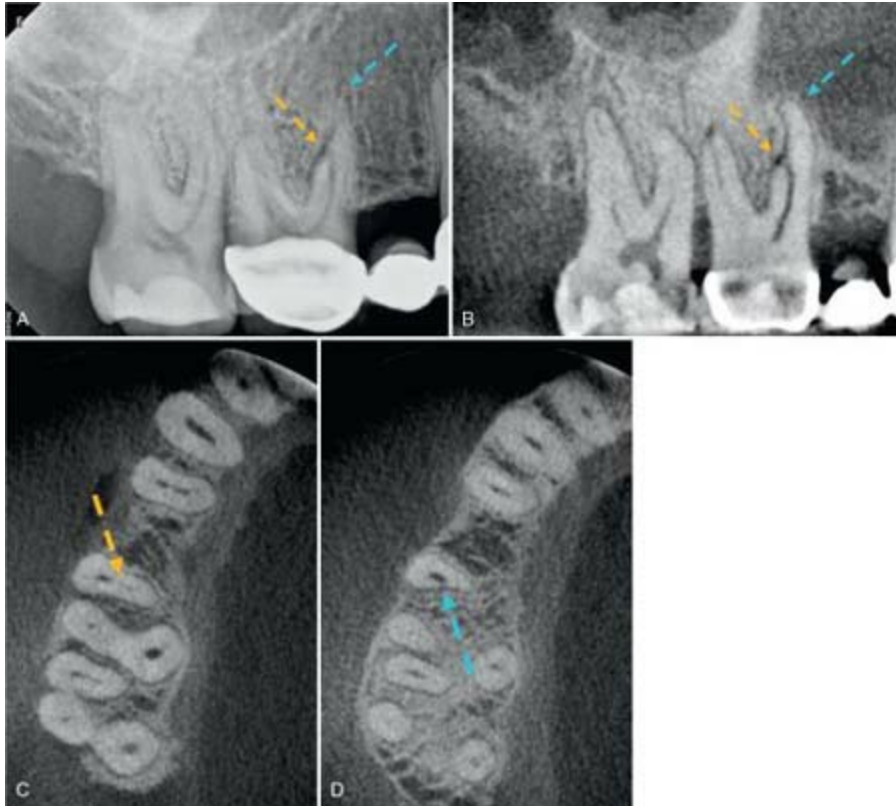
This patient was referred for evaluation and possible treatment after emergency pulp extirpation performed by others. A, This PA radiograph shows that the location of the physiologic terminus (*yellow arrow*) and radiographic apex (*blue arrow*) did not appear to coincide within the normal range. B, Contemporaneous CBCT sagittal reformation shows the anomalous location of the physiologic terminus (*yellow arrow*) and radiographic apex (*blue arrow*). C, Presence of a mesioaccessory canal with isthmus (*blue arrow*) and (D) an oval-shaped canal (*yellow arrow*) is apparent.
